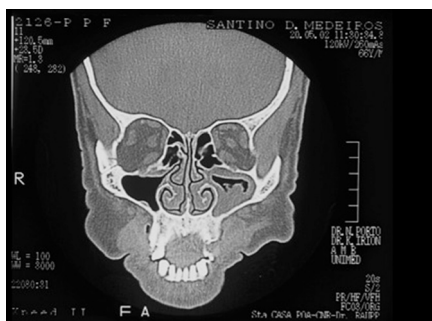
CT scan of the head of a patient with *P. boydii* fungus ball demonstrating opacified left maxillary sinus and clear right maxillary sinus.
